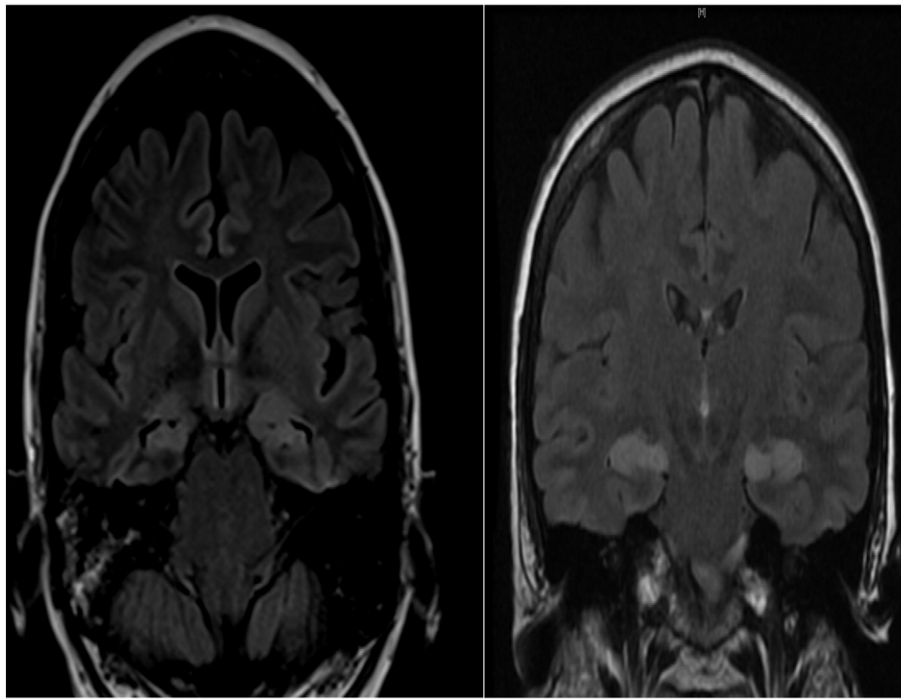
Coronal FLAIR MRIs showing hyperintensities in the bilateral mesial temporal lobes.
